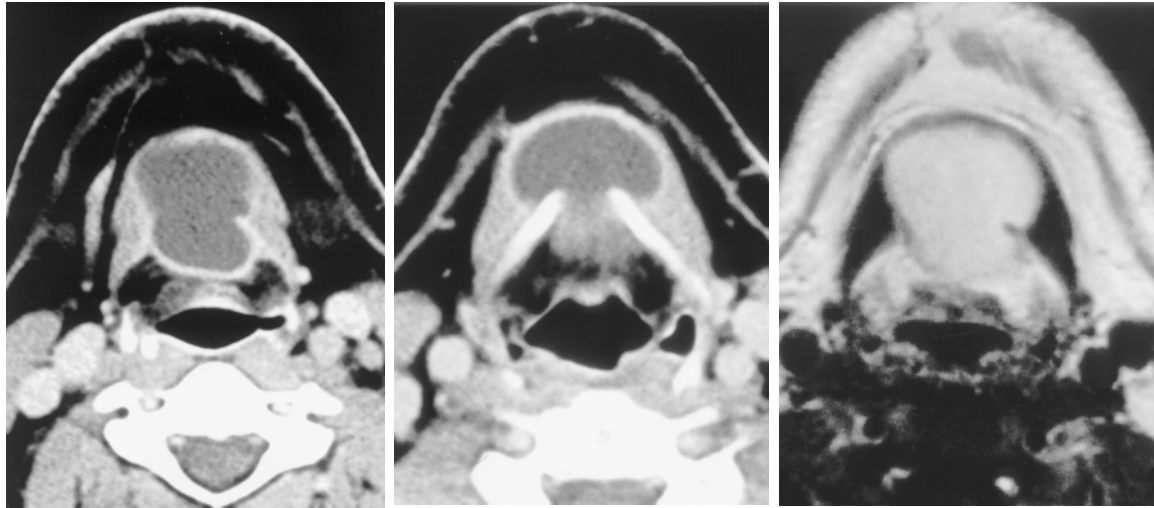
Thyroglossal duct cyst in a 41-year-old man. (a, b) Axial contrast-enhanced CT scans show a cystic mass in the anterior midline of the neck just above (a) and at the level of (b) the hyoid bone. (c) Axial T1-weighted MR image at the thyrohyoid membrane level shows hyperintensity of the mass, a finding suggestive of proteinaceous content or hemorrhage.
